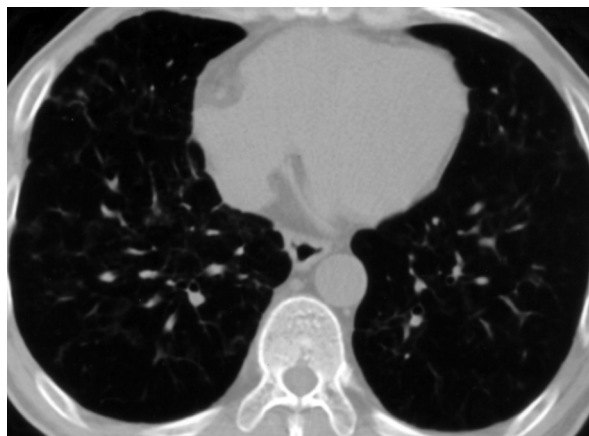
Chest CT with a lung window view shows near resolution of the pulmonary nodules, some ground-glass opacity, and mild thickening of the interlobular septa of both lungs.
